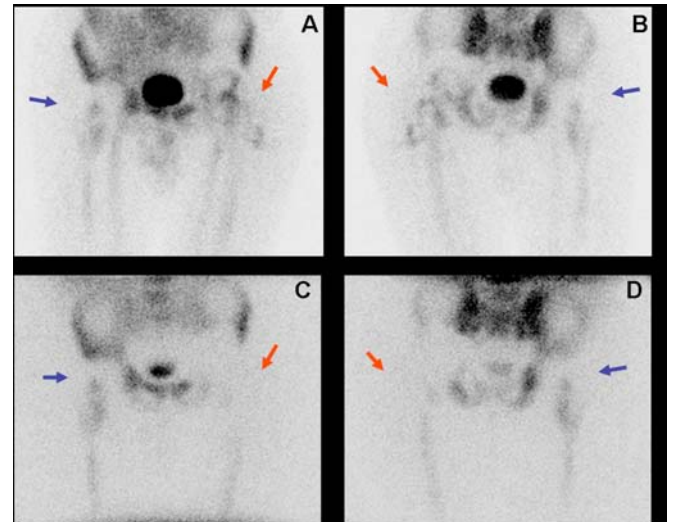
The figure presents a patient with bilateral prosthesis and confirmed infection of the left hip. The leukocyte scintigraphy images (A: anterior, B: Posterior) show focal deposits in the left coxofemoral joint with fistulous trajectory towards the outer side of the thigh, inconsistent with the marrow scintigraphy (C: Anterior, D: Posterior), suggesting active infection (big arrows). Note that marrow scintigraphy findings are consistent with the leukocyte scintigraphy in the non-infected right hip prostheses (small arrows).
